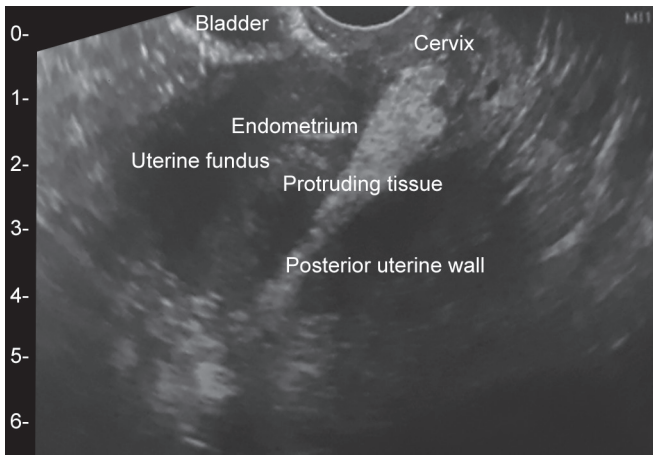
Ultrasound picture of the uterus with posterior perforation and tissue invagination
